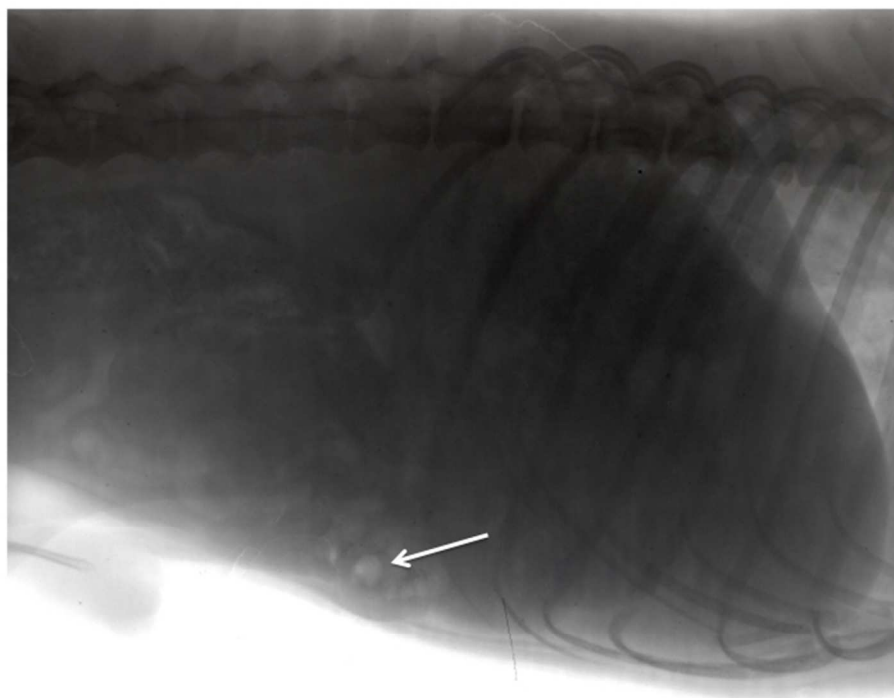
X-ray picture of beagle stomach 4 h from the administration.
